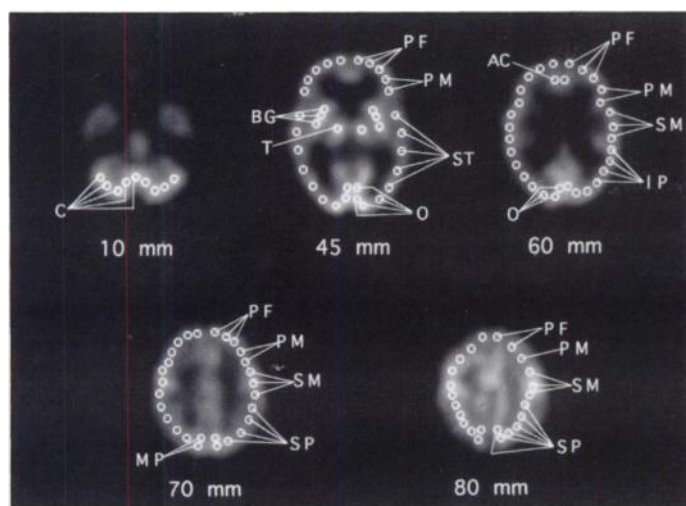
Region of interest (ROI) template used in the SPECT analysis. The millimeter specification below each slice is the distance above the canthomeatal plane. C = cerebellum; BG = basal ganglia; T = thalamus; PF = prefrontal cortex; PM = premotor cortex; ST = superior temporal cortex; O = occipital cortex; AC = anterior cingulate cortex; SM = sensorimotor cortex; IP = inferior parietal cortex; MP = medial parietal cortex; SP = superior parietal cortex.
